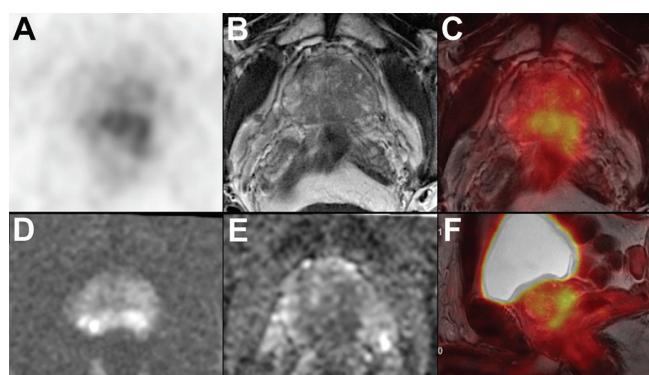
Sixty-nine-year-old patient with Gleason score 4+3 prostate cancer detected by prostate 12-core needle biopsy under transrectal ultrasonography guidance. His serum prostate specific antigen level was 27.0 ng/mL at the time of diagnosis. Axial Ga-68 prostate specific membrane antigen (PSMA) positron emission tomography (PET) (A), axial T2-weighted magnetic resonance imaging (MRI) (B), fused PET/MRI (C), FOCUS diffusion weighted imaging for b=1400 s/mm² (D), apparent diffusion coefficient (ADC) map for b=800 s/mm² (E) and sagittal fused PET/MRI (F) images exhibited PSMA-positive tumor located at bilateral peripheral zone of the prostate gland (SUV_{max}: 6.7, SUV_{mean}: 6.1, ADC: 1.18 s/mm² for region of interest (ROI)-1 and SUV_{max}: 6.6, SUV_{mean}: 5.5, ADC: 1.09 s/mm² for ROI-2). The patient did not have any lymph node or organ metastasis according to the PSMA PET images
